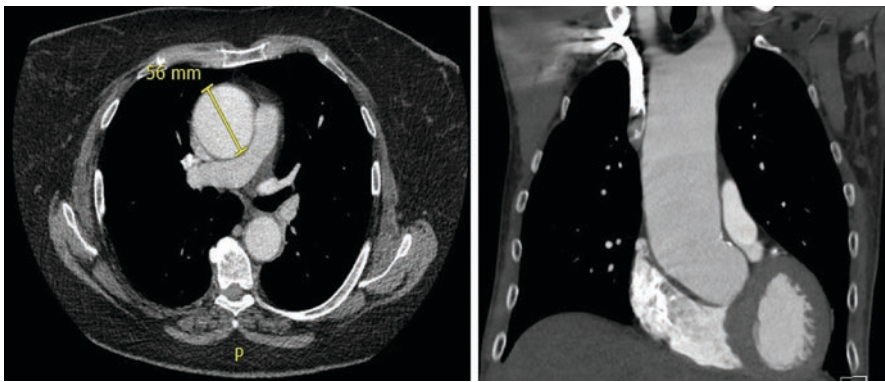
Axial and sagittal contrast CT scan showing an isolated ascending aortic aneurysm
